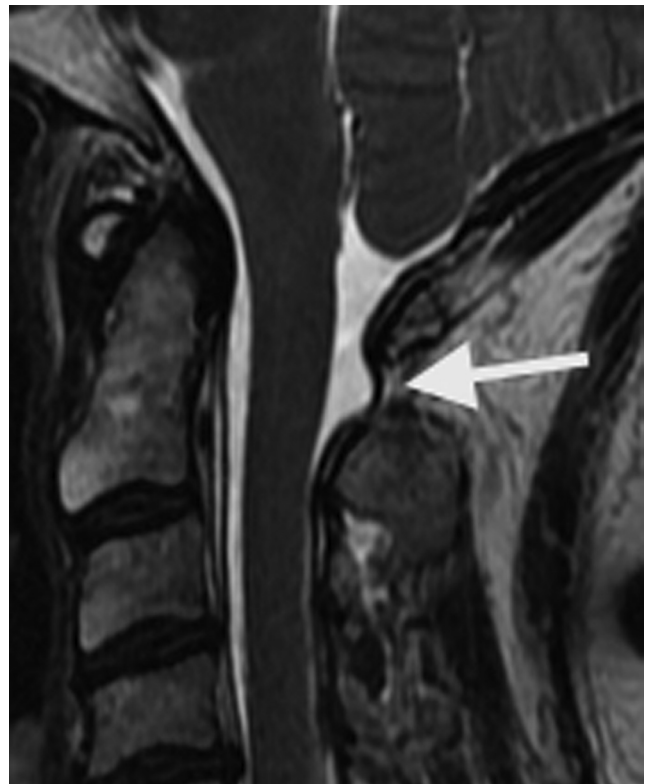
Sagittal T2 MR image of the cervical spine shows the dural diverticulum between the posterior elements of C1 and C2 (arrow).
